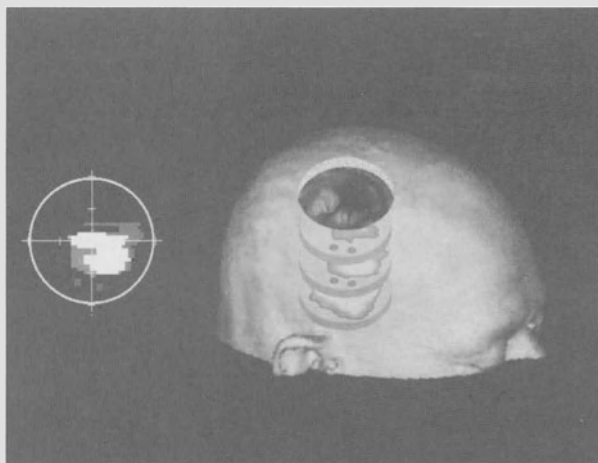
Interactive MEG Guidance and computer-assisted volumetric resection. Right: A three-dimensional MRI reconstruction of the patient's head is shown. Volumetric cross-sectional levels (1 mm thick) through the tumour are depicted underneath an intraoperative photograph of the tumour and surrounding brain tissue. The MEG source dipoles for motor and sensory cortex are shown on the relevant cross sections as grey circles. Left: A representative sample of the cross sectional data as it appears in the COMPASS stereotactic database. This corresponds to the middle section (right figure part). The circle represents the 1.5 inch diameter bony trephine. The cross-sectional tumour volume derived from the contrast-enhanced CT and T1 MRI with contrast is depicted in white and grey, respectively. The location of the MEG motor and sensory dipoles in stereotactic space are seen as grey squares
